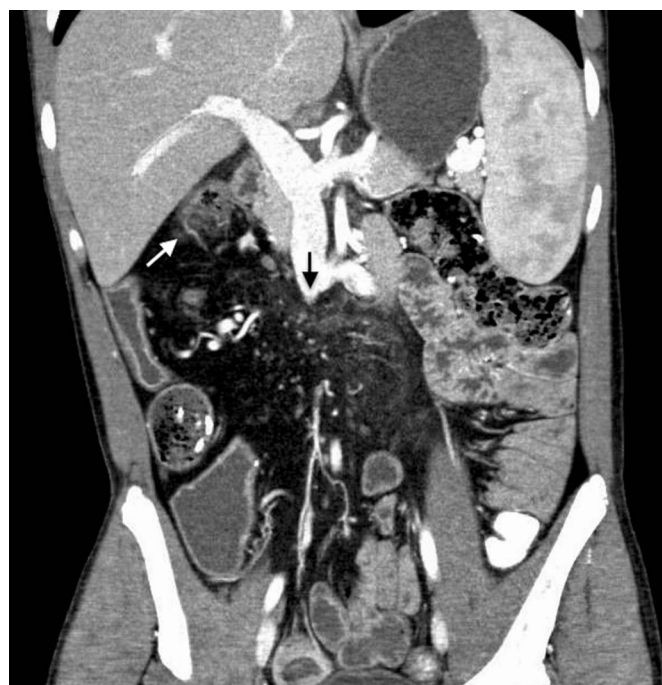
Abdominal computed tomography demonstrating superior mesenteric vein occlusion (black arrow) and consequent collateralization at the hepatic flexure (white arrow).
